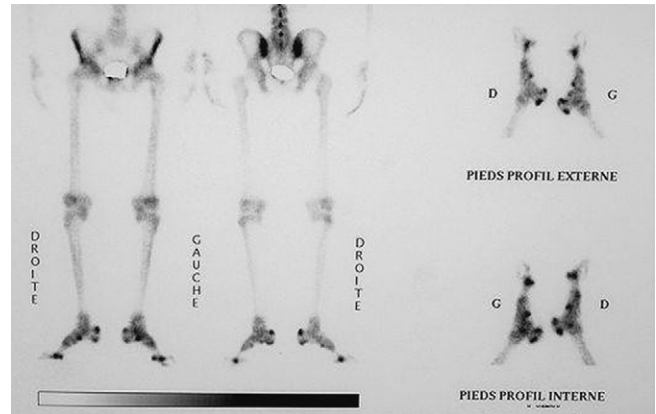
Bone scan showing a significant uptake in heels and feet, linked to polyenthesitis on MRI.
